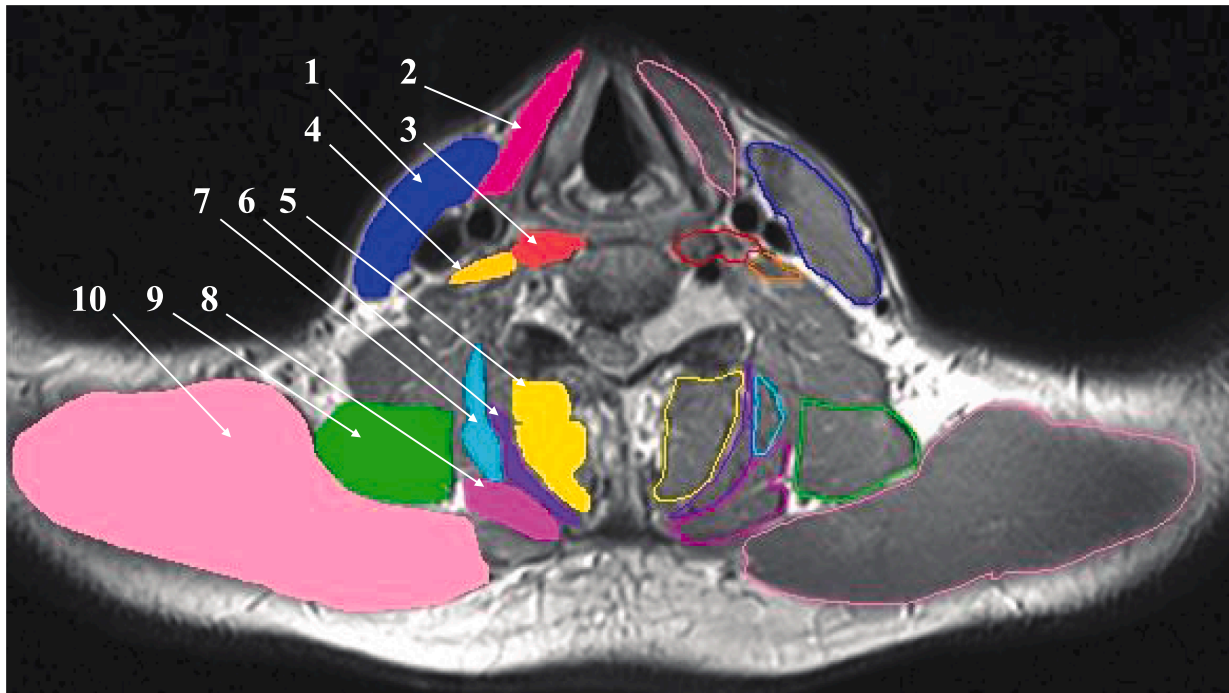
Segmented muscle bodies in a cross-sectional MRI at the C6 level: 1. sternocleidomastoid (SCM); 2. infrahyoid muscles (IH); 3. longus colli and longus capitis (Longus); 4. anterior scalene (AS); 5. semispinalis cervicis and multifidus (Deep); 6. semispinalis capitis (SSC); 7. longissimus cervicis and longissimus capitis (Longiss); 8. splenius capitis and splenius cervicis (SPL); 9. levator scapula (LS); and 10. trapezius (Trap).
